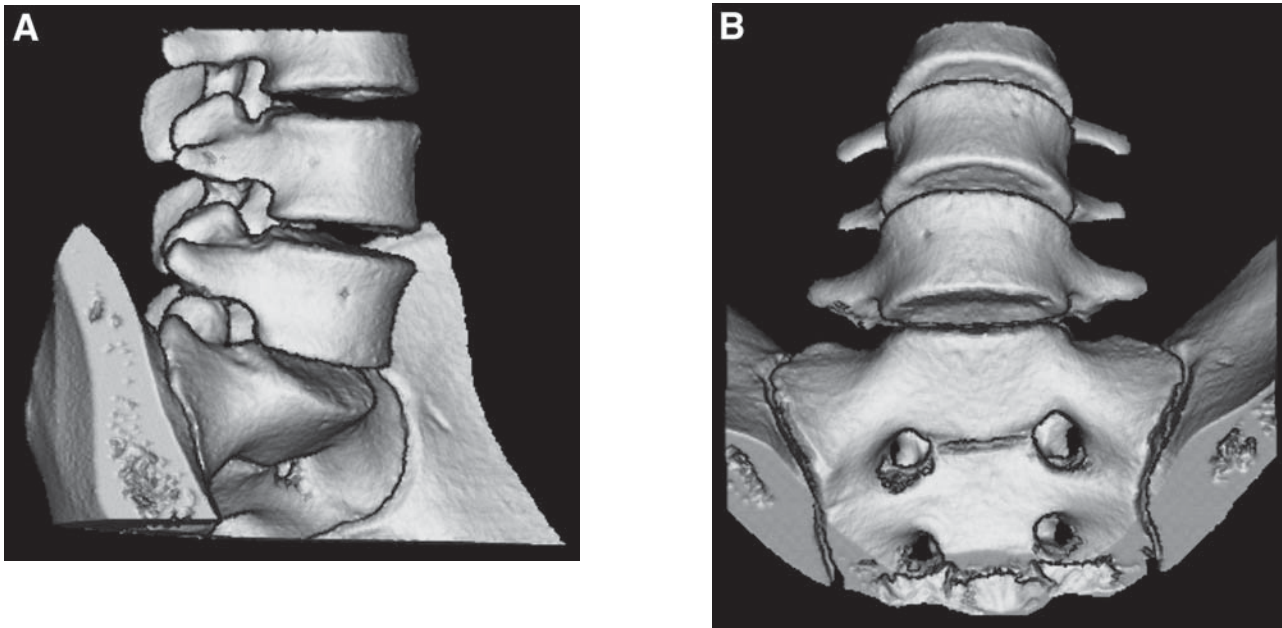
(A, B) CT three-dimensional reconstruction of the lumbar spine and pelvis. (Courtesy of Philips Medical Systems, Bothell, WA)
